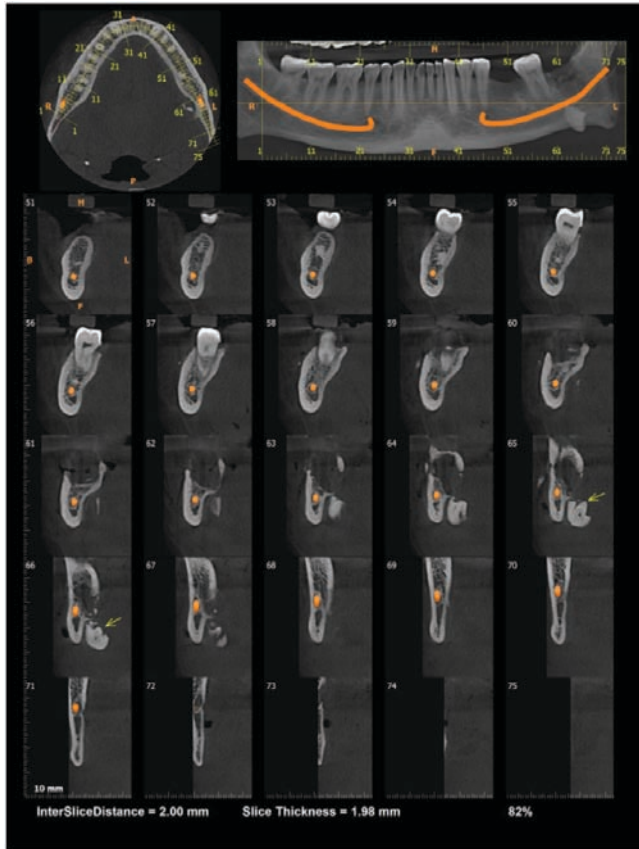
CBCT revealing fractured lingual plate and displaced root i.r.t 38
